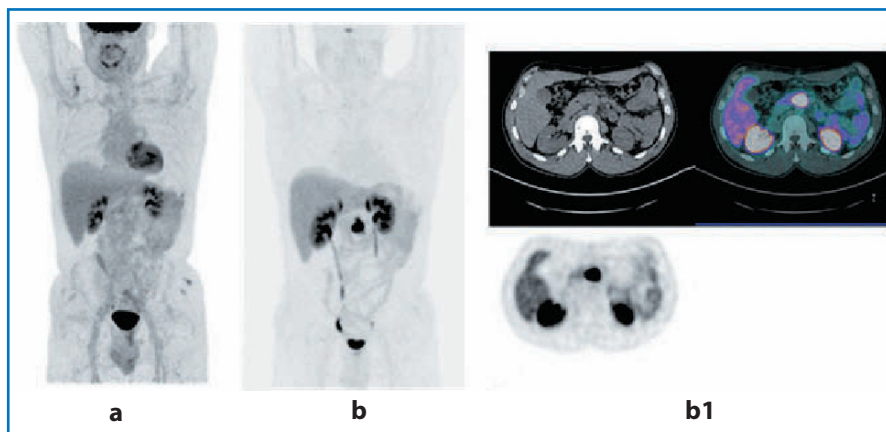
G2 pancreatic NET (Ki-67 12%) in a 48-year-old man. a Baseline negative FDG PET. b Baseline ^{68}Ga -DOTA-peptide PET with evidence of pancreatic lesion. b1 Baseline ^{68}Ga -DOTA-peptide PET with evidence of pancreatic lesion not clearly defined by morphologic imaging
